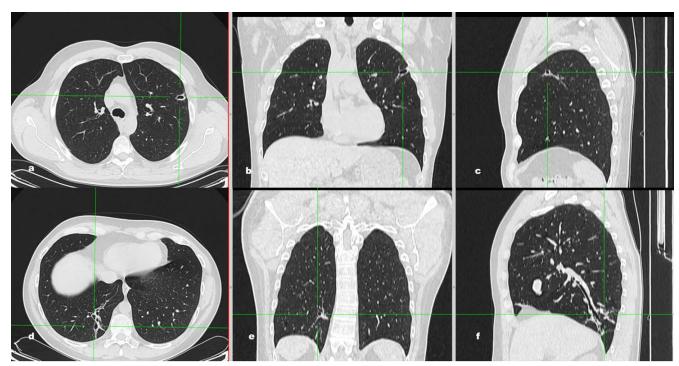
(6a-f) One-month radiological follow-up with axial (6a,6d), coronal (6b,6e) l and sagittal (6c,6f) thin-section CT scan (lung windowing) after pharmacological therapy. The consolidations on the superior lingular segment of the left upper lobe and on the posterior segment of the right lower lobe have disappeared. In both regions some fibrotic changes characterized by small traction bronchiectasis remain.
